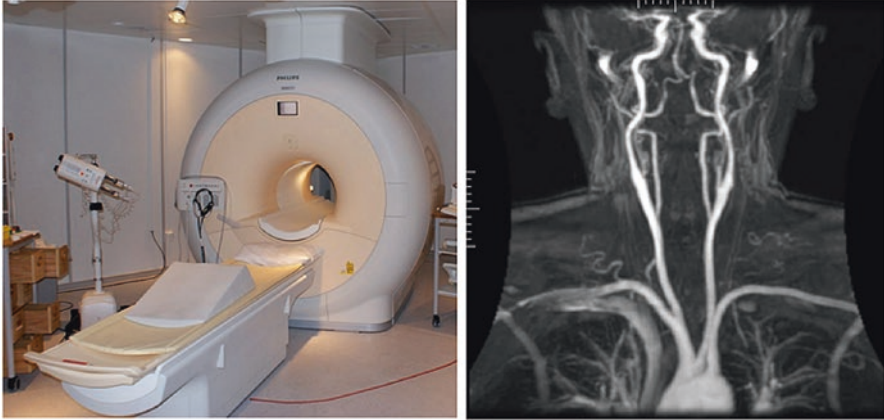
Magnetic resonance imaging (MRI). *Left:* A MRI machine in the hospital (<https://commons.wikimedia.org/wiki/File:MRI-Philips.JPG>). *Right:* Magnetic resonance angiography (MRA), pictures of the arteries (<https://commons.wikimedia.org/wiki/File:Mr1.jpg>)
